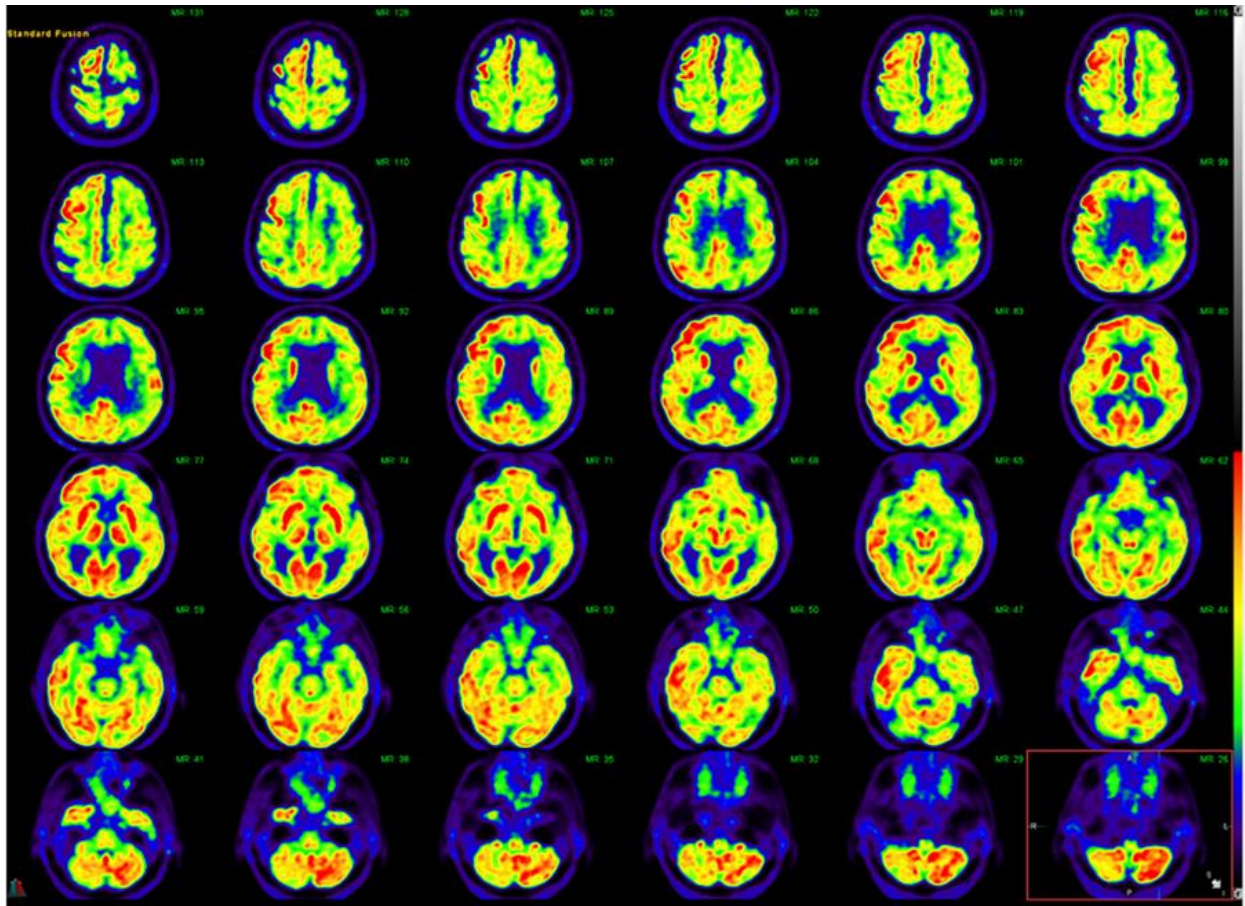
Serial fusion FDG-PET and FLAIR axial views of a 75-year-old male with metabolic and structural imaging findings suggestive of underlying corticobasal degeneration, with associated crossed cerebellar diaschisis. Specifically, there is abnormal FDG distribution pattern with striking supratentorial asymmetry and decreased radiotracer uptake in nearly the entire left cerebral hemisphere. Marked hypometabolism is evident particularly in the left frontoparietal region including in the left sensorimotor cortex with decreased uptake also noted in the ipsilateral left basal ganglia and left thalamus. There is corresponding hypometabolism in the contralateral right cerebellar hemisphere, findings compatible with crossed cerebellar diaschisis.
